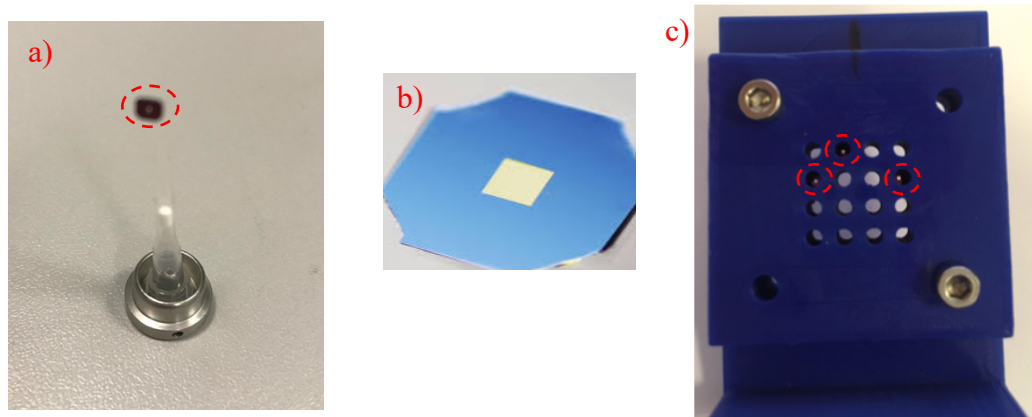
Silicon nitride window holders for X-ray imaging. a) A single grid holder, prepared on a SEM stub, b) Square shaped silicon nitride membrane at the centre of a 3 mm octagonal silicon frame and c) 3D printed 4 x 4 array of grid holder which contains 3 silicon nitride windows (red dashed circle).
